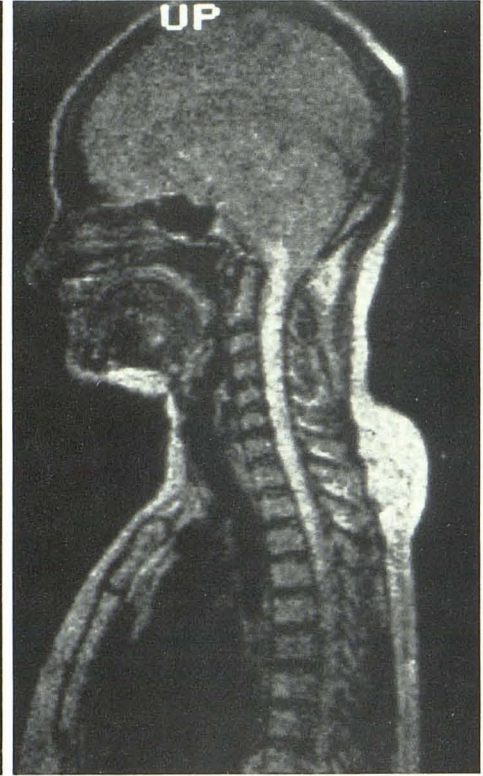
T2-weighted MR image (TE 70, TR 1700) with body coil shows lower extent of lesion more accurately. Prominent posterior fat collection was positional. The patient had not previously received exogenous steroids.
